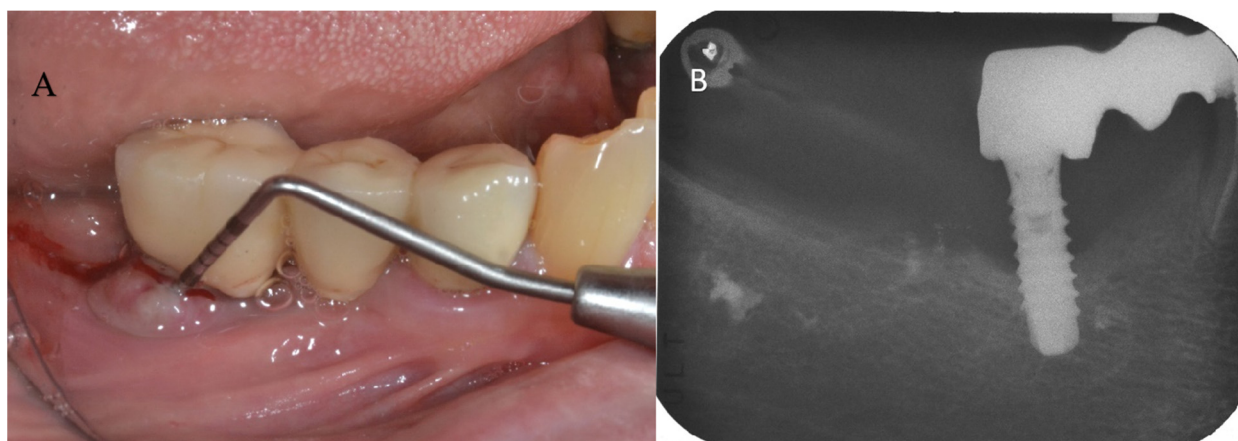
Peri-implantitis of the distal implant revealed by the probe (A) and the radiograph (B).
